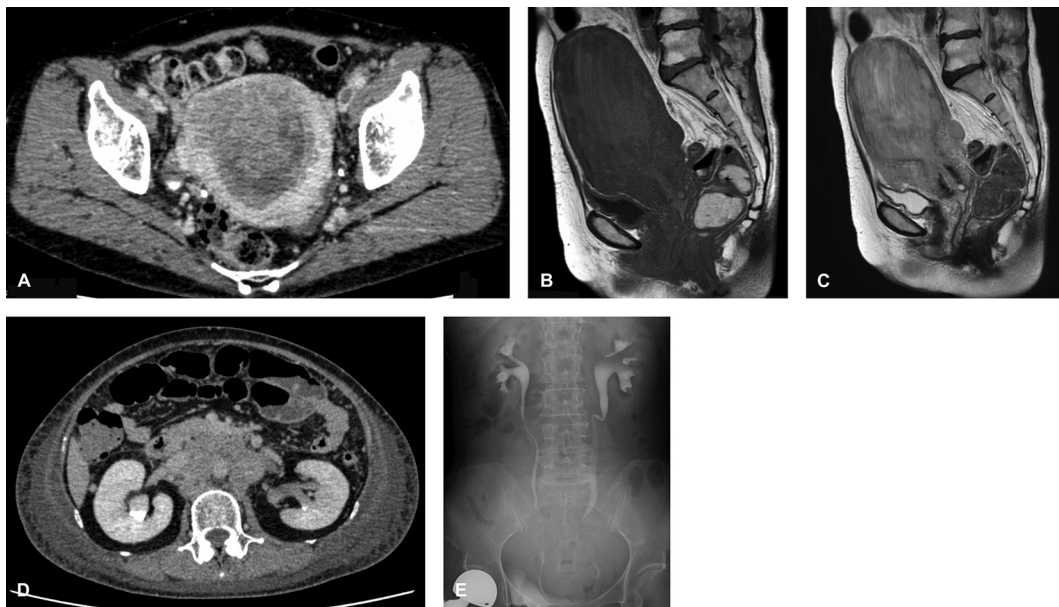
Radiological features of the uterine tumor and hydronephrosis. Contrast-enhanced computed tomography (CT) showed the large solid uterine tumor with heterogeneous enhancement (A). Magnetic resonance imaging showed the uterine tumor with slightly heterogeneous hypointensity on T1-weighted imaging (B) and hyperintensity on T2-weighted imaging (C). CT showed prominent para-aortic lymph node metastases (D), resulting bilateral hydronephrosis (drip infusion pyelography; E).
